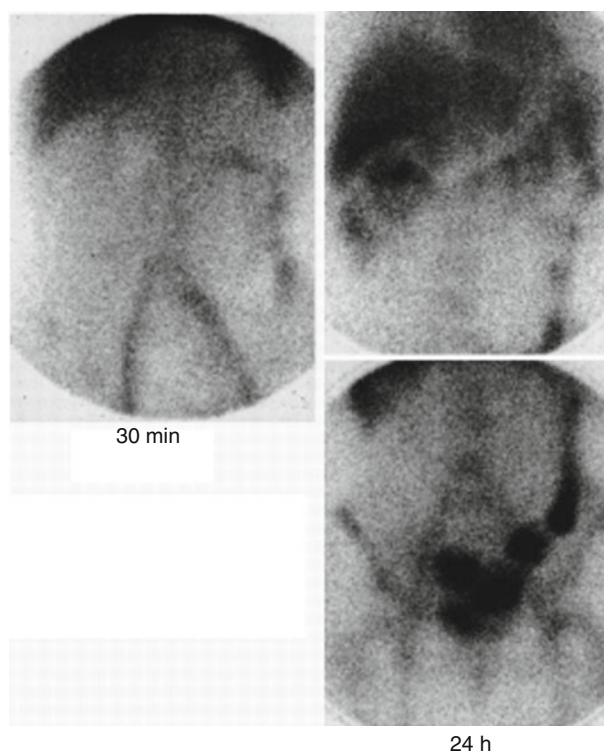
Massive gastrointestinal bleeding. Technetium-99m-RBC scintigraphy from a teenage girl with uncontrollable gastrointestinal bleeding for several years. The image on the *left* (30 min postinjection) reveals bleeding in a portion of the small bowel. Images 24 h later (*right panel*) reveal tracer within the entire course of the colon. The patient had a small bowel resection in which a cluster of veins was found
